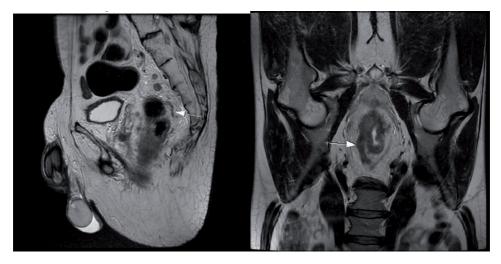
EMVI- extramural venous/vascular invasion (T2 weighted MR images).
